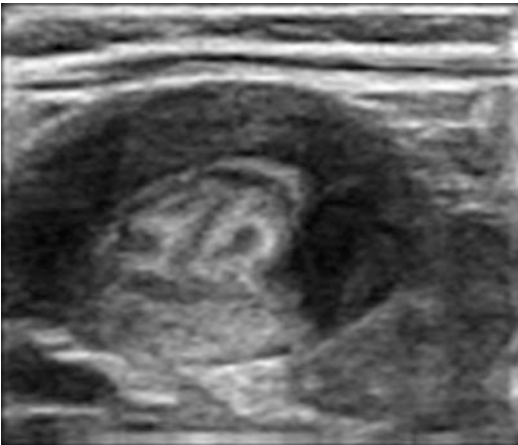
Ultrasound transversal scan shows “target” sign due to hypertrophied hypoechoic muscle surrounding echogenic mucosa
